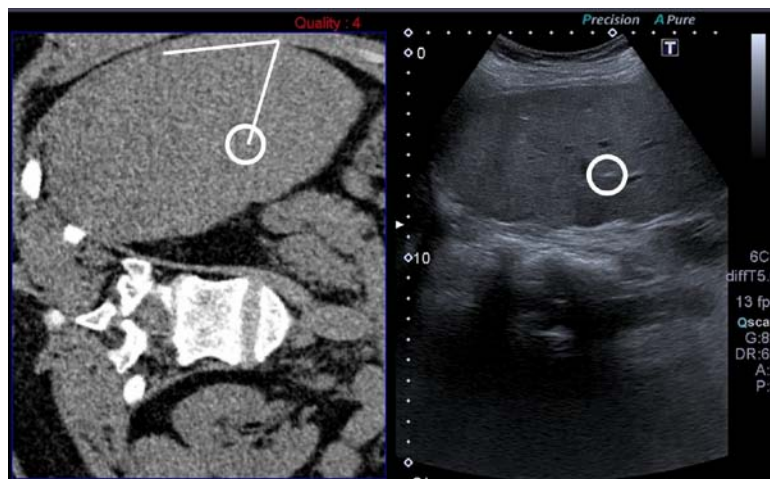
Virtual CT image (left side) and corresponding real-time US image (right side) used for the insertion of the 22G needle in the liver. Distance between the tip of the needle (white point in the circle on US image) and the liver capsula and angulation between the needle and the tangent of the capsula are calculated on the US image and reported on the CT image.
